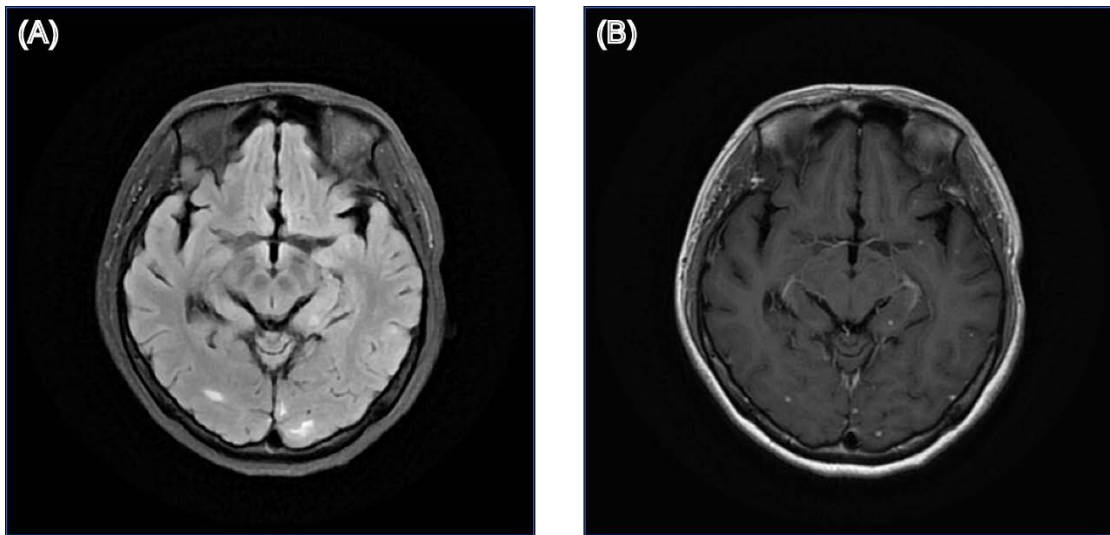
Structural brain MRI images of patient 20. (A) T2-weighted fluid-attenuated inversion recovery (T2-FLAIR) image; (B) Gadolinium-enhanced T1-weighted (Gd-T1w) image.
